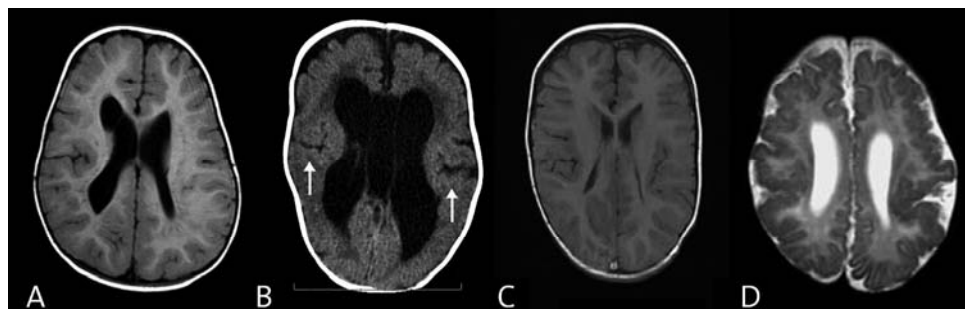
Brain imaging. (A) T1 weighted axial brain MRI of patient 1 at the age of 2 years showing asymmetry of lateral ventricles with right-sided porencephalic cystic dilatation and perisylvian polymicrogyria (arrows). (B) Brain CT scan of patient 2 at the age of 1.5 years showing hydrocephalus and bilateral wide sylvian fissures and cortical anomaly compatible with perisylvian polymicrogyria. (C) T1 weighted axial brain MRI of patient 3 at the age of 3 years, showing prominent frontal lobes and no polymicrogyria. (D) T2 weighted axial brain MRI of patient 8 at the age of 3 months, showing enlarged lateral ventricles and bilateral cortical polymicrogyria most prominent in perisylvian areas.
